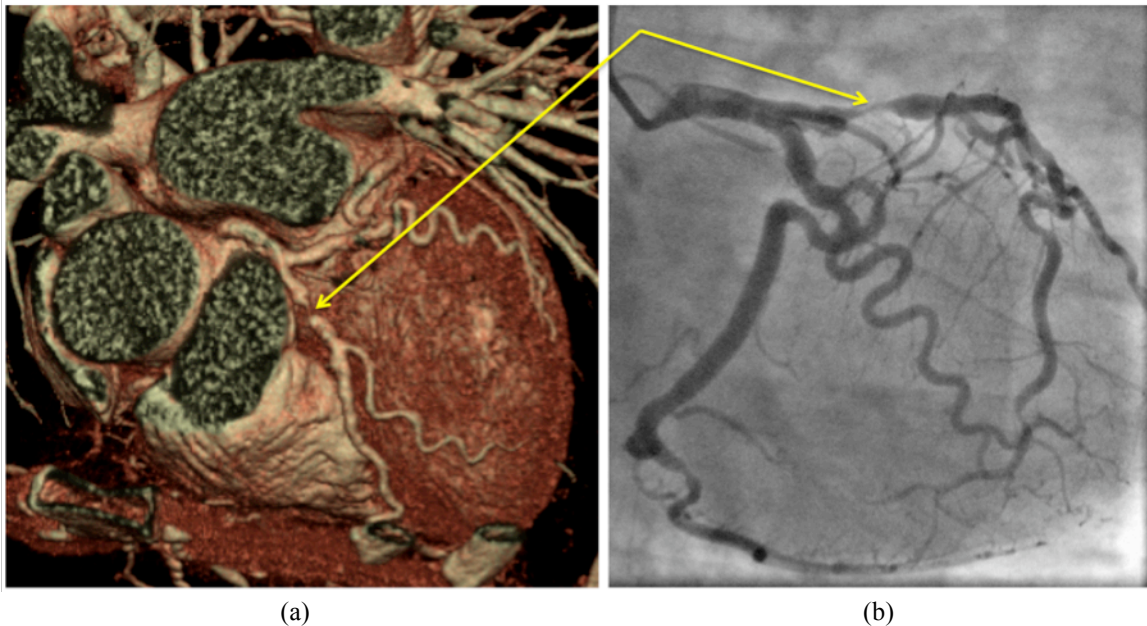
Transaxial view of a contrast-enhanced CTA (a) and corresponding angiogram (b). Yellow arrows point to site of occlusion.
